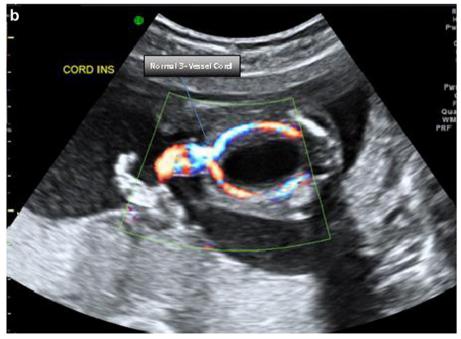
a. Prenatal ultrasound at 18 weeks gestation. b. Prenatal ultrasound at 18 weeks gestation with power doppler signal.
